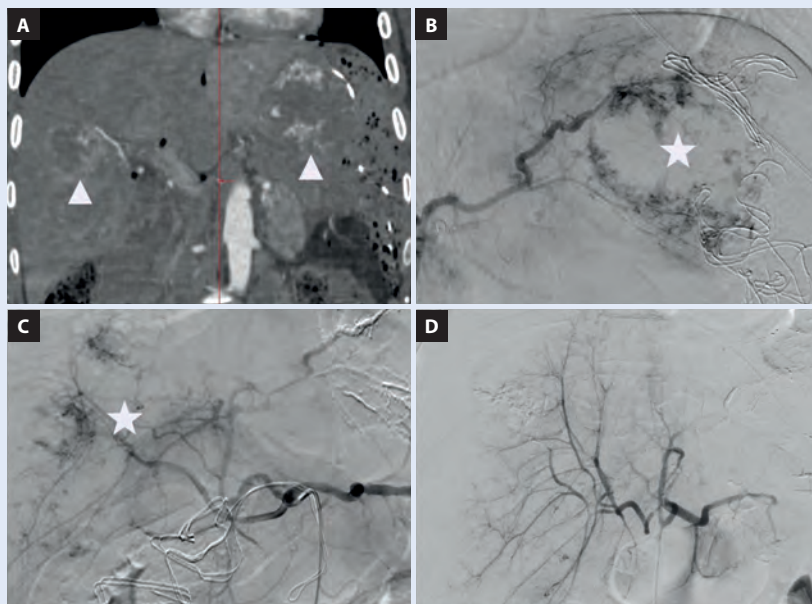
A. Post-operative computed tomography showing numerous intrahepatic foci with contrast enhancement typical of hemangiomas (white triangles); B, C. Digital subtraction angiography (DSA) examination showed pathological vascular beds in the liver with visible active extravasation of contrast agent (white star). Embolization was performed using a mixture of glubran glue and lipiodol; D. Control angiography showed complete exclusion of the lesions
